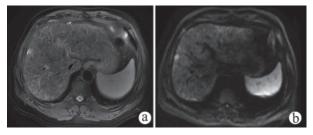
MRI feature of a small HCC associated with liver cirrhosis. (a) A moderate hyperintense nodule was revealed on fast suppressed T2WI sequence in the right margin, many small hypointense nodules could be seen in the background parenchyma suggesting the existence of cirrhosis. (b) The small HCC demonstrate remarkably hyperintense on diffusion weighted images, suggesting restriction of water molecule movement in the tumor.
